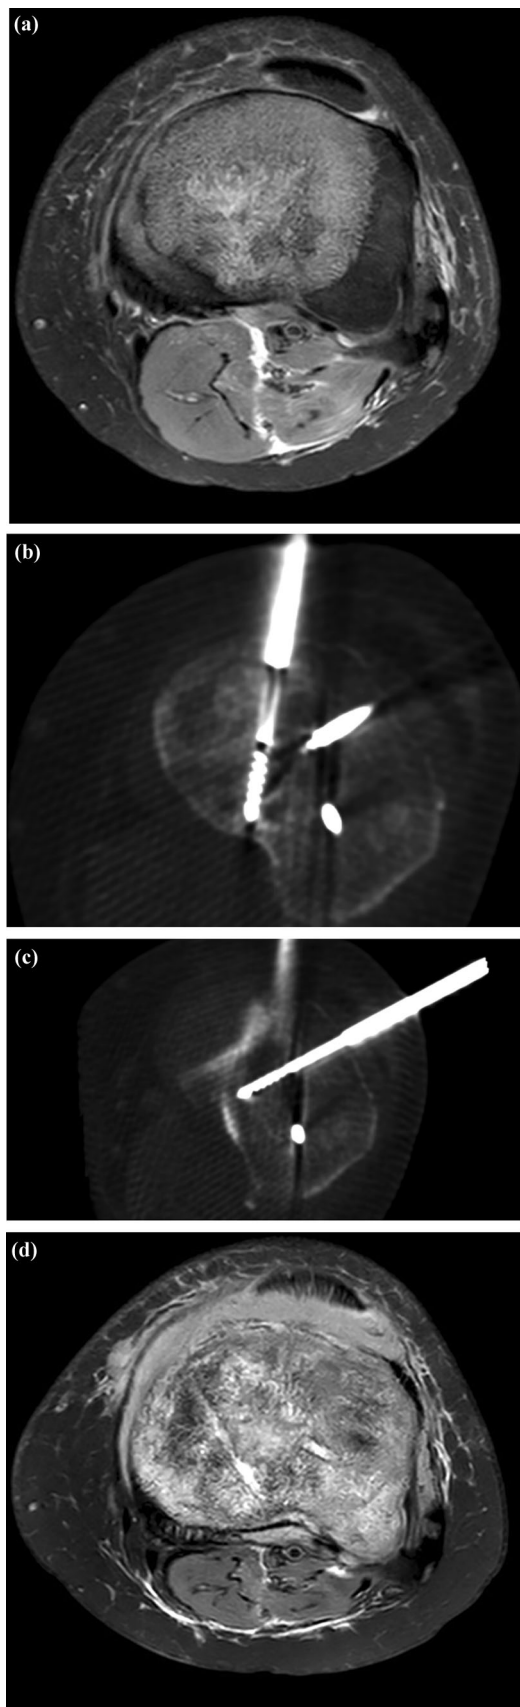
a Tibial Ewing sarcoma causing invalidating pain in a 10-year-old patient (visual analogue scale = 8). b and c Cone-beam computed tomography-guided percutaneous cryoablation. d MRI control after treatment showing ablated zone, clinically the pain improved significantly (VAS = 2)
